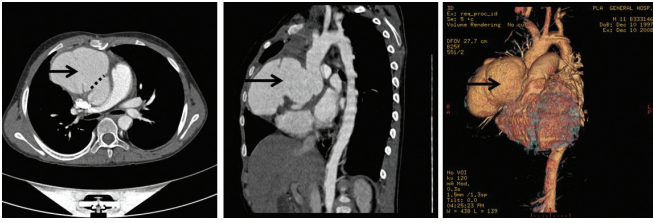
Preoperative computed tomographic scan of the patient. The dotted line shows the defect in the anterior wall of the ascending aorta. Arrows show the pseudoaneurysm arising from the right anterior wall of the ascending aorta.
